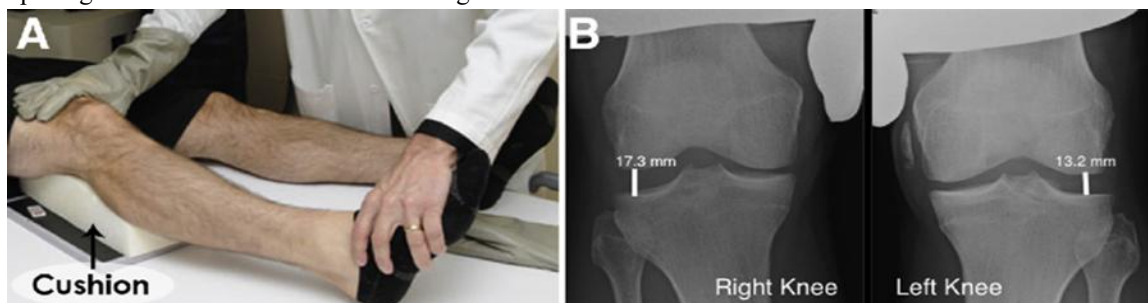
(A) The image demonstrates varus stress positioning of the right knee with support to apply controlled lateral compartment stress in a patient with suspected posterolateral corner injury. B) The comparative bilateral radiographs reveal a side-to-side difference in joint space width, consistent with a complete posterolateral corner injury.
